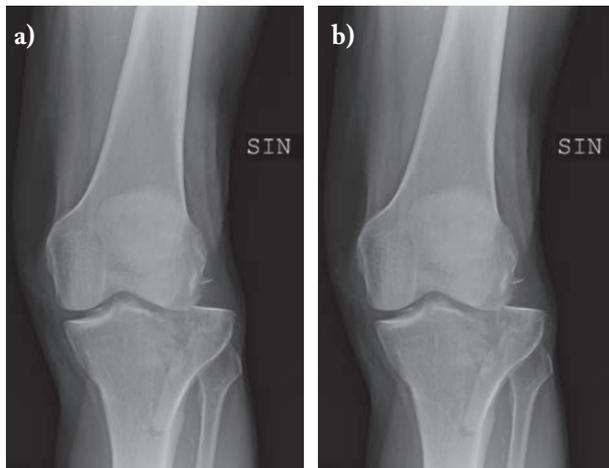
a, b) Radiographs of a 68 year-old-male patient with a tibial plateau type VI fracture according to the Schatzker classification
